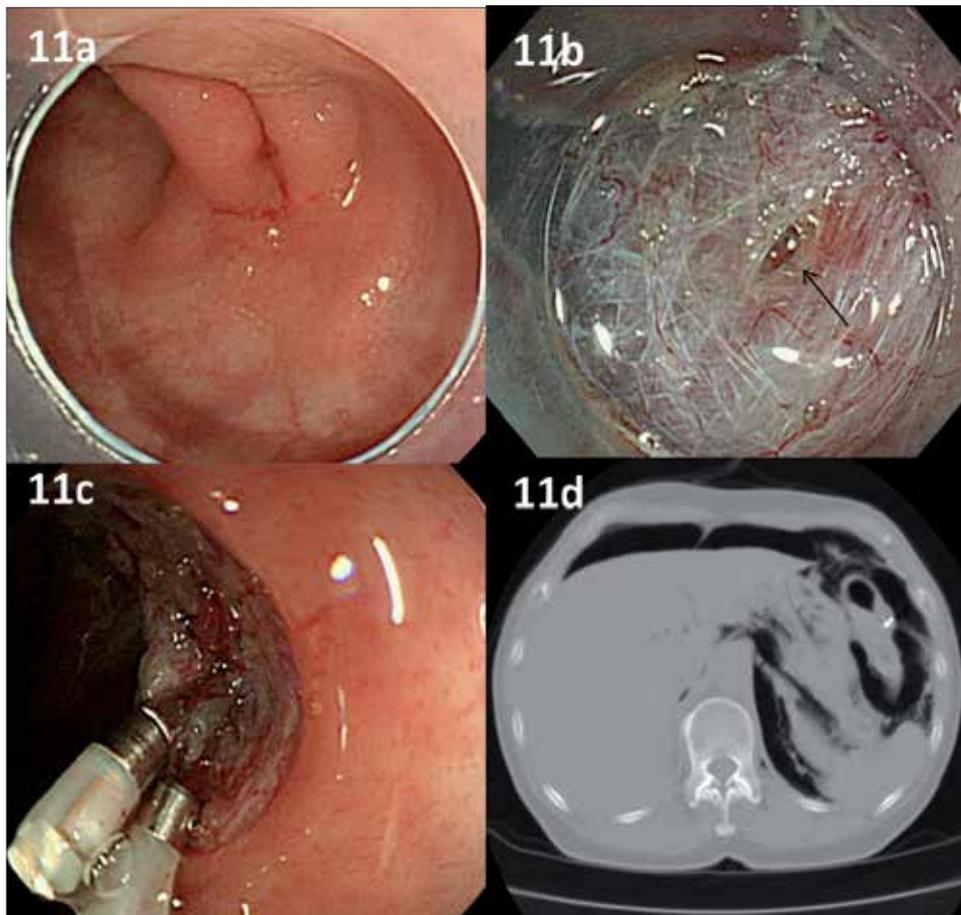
Perforation during ESD. 11a: 0–IIa 30 mm on the descending colon. 11b: Coagulation to submucosa during resection of submucosa below the tumor caused perforation (black arrow). 11c: The hole was closed by endoscopic clipping. 11d: CT revealed free air out side of the colorectum.
